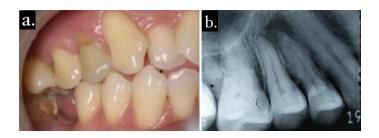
Pre-operative clinical photographs and radiographs.
